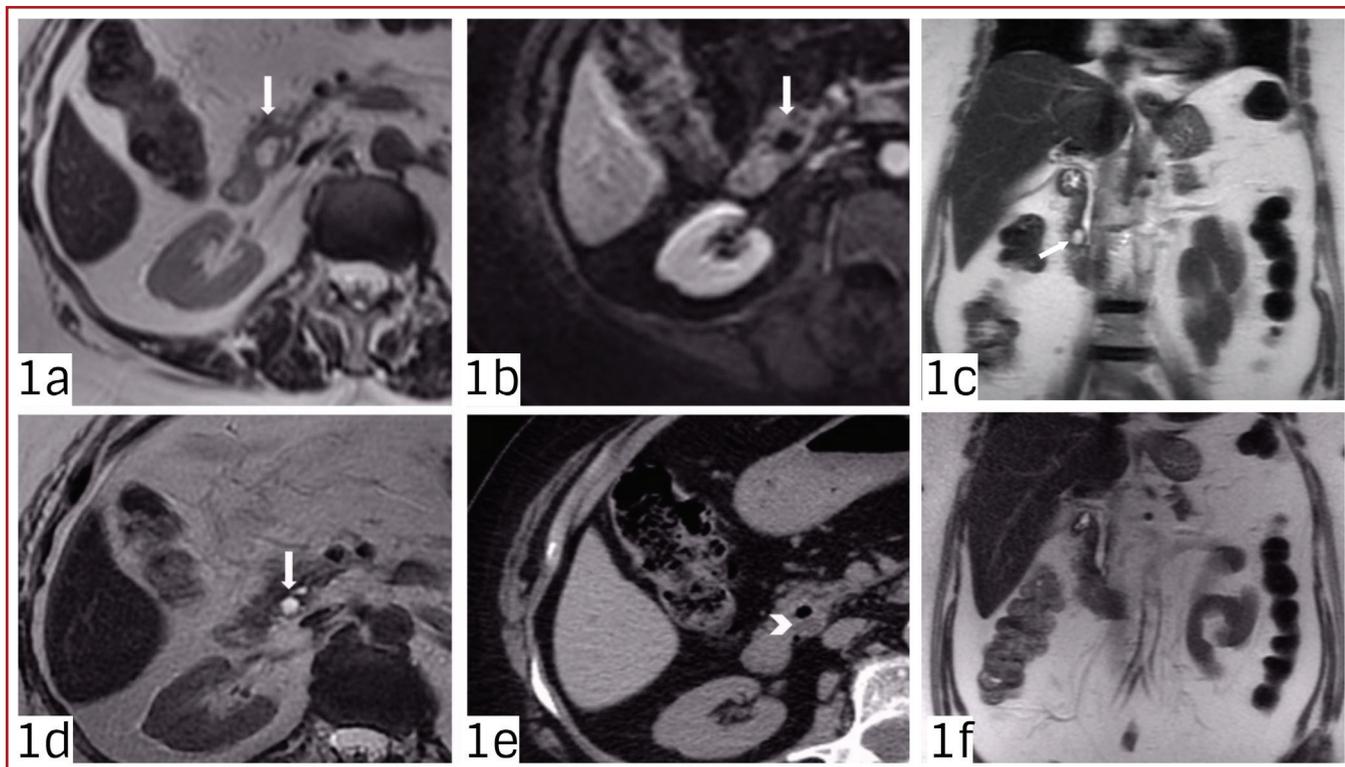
Axial T2-weighted MR image shows a duodenal diverticulum mimicking a pancreatic cystic lesion at the level of pancreatic head (Figure 1a) and on axial enhanced T1-weighted MR image lesion does not enhance with contrast medium (Figure 1b). At follow-up imaging, after one year, change in size and shape of the lesion is seen on axial T2-weighted MRI (Figure 1d). On axial contrast-enhanced CT image, air-fluid level is seen within the lesion (Figure 1e). Coronal T2-weighted MR images demonstrates duodenal diverticulum localized adjacent distal choleducus (1c). One year later, duodenal diverticulum could not be demonstrated on coronal images due to decreased size of the diverticulum and thick slices of MRI.
